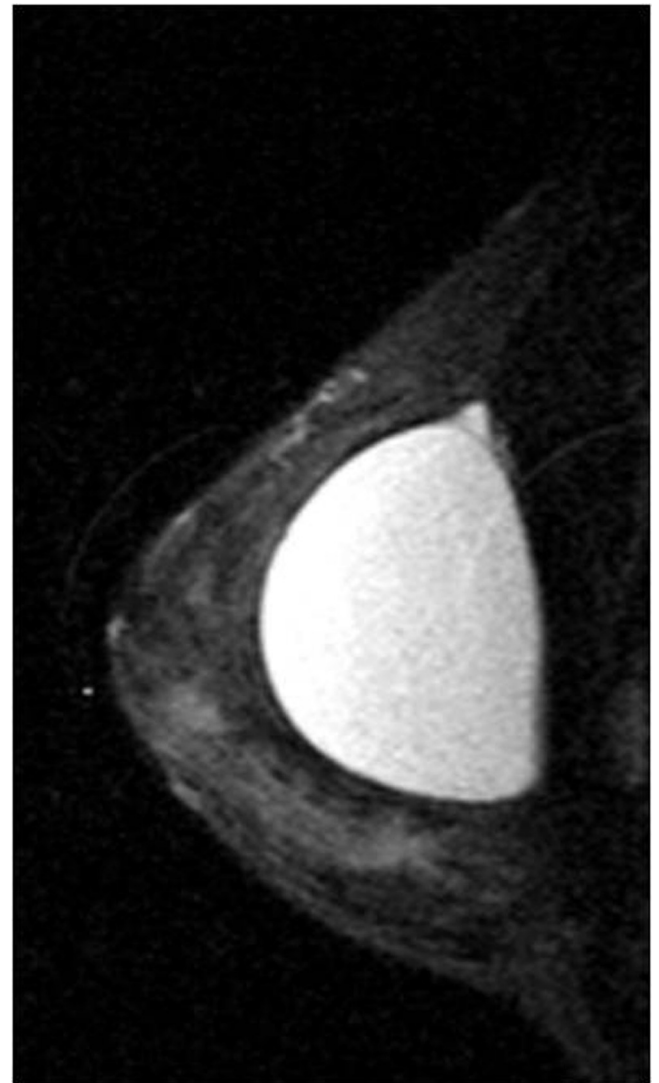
Typical appearance of Macrolane following placement as a single implant (12 months post-treatment) on MRI (sagittal STIR).
